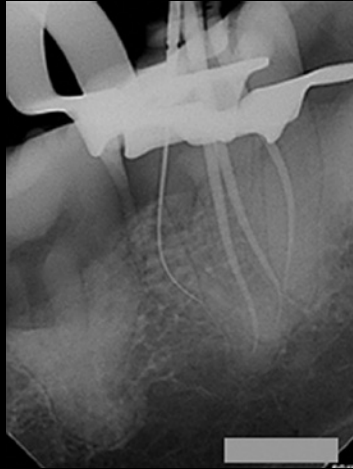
Working length/cone fit radiograph.
